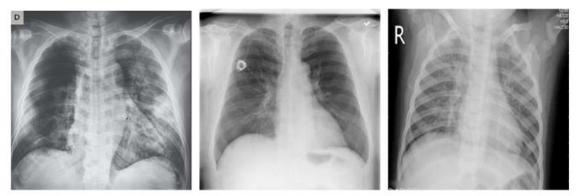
Chest X-Ray images Sample from the Dataset
